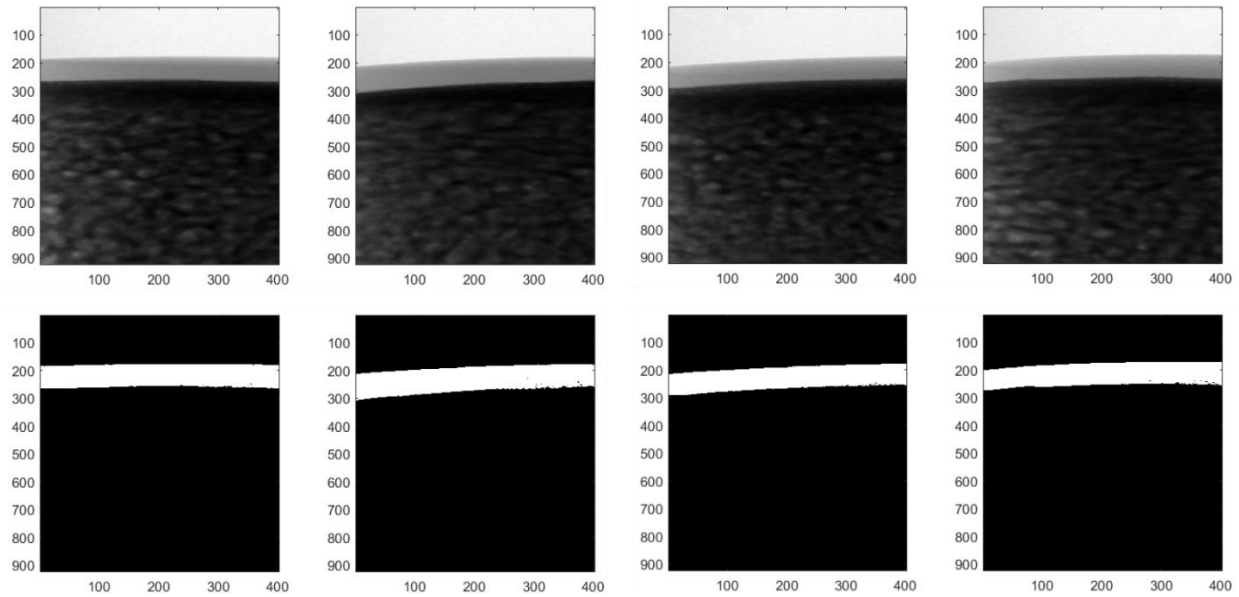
(Top) Planar images acquired by μ CT, each one obtain after a rotation of 45° around the sample vertical axis. (Bottom) Binarization of the planar images, obtained after applying the developed procedure, from which AC thickness was computed.
